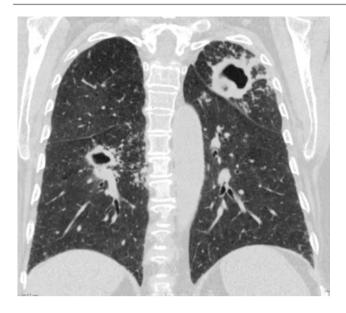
A 73-year-old diabetic woman with septic pulmonary embolism and UTI. (a, b) Axial CT images show solid nodule with "halo" sign in the left upper lobe and a cavitary nodule with an air-fluid level in the right upper lobe
